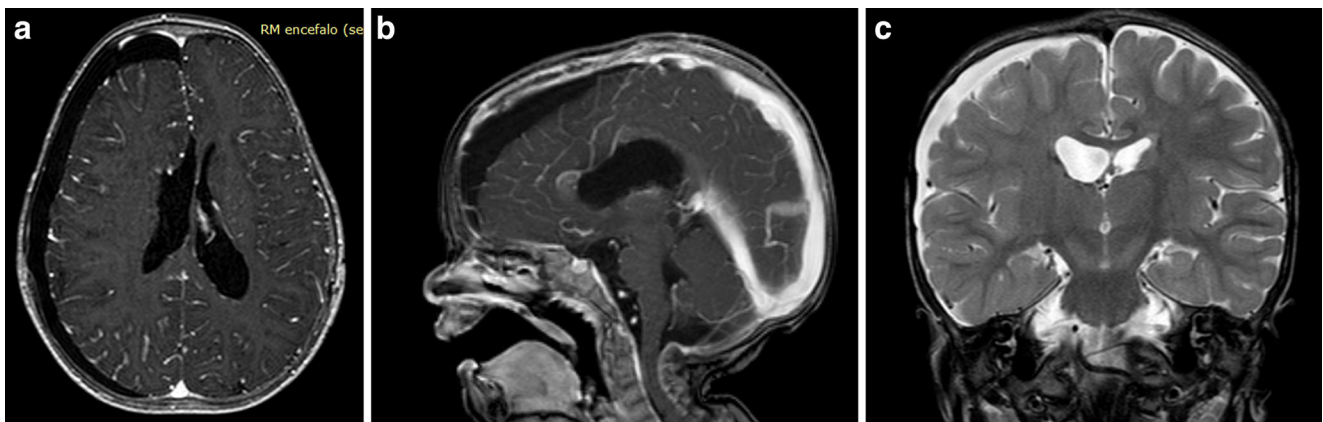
1-year follow up of the same case as Fig. 1. Axial (a) and Coronal (b) contrast-enhanced MRI showed complete resection of the lesion with no recurrences. Coronal T2 WI MRI (c) showed resolution of perifocal edema
